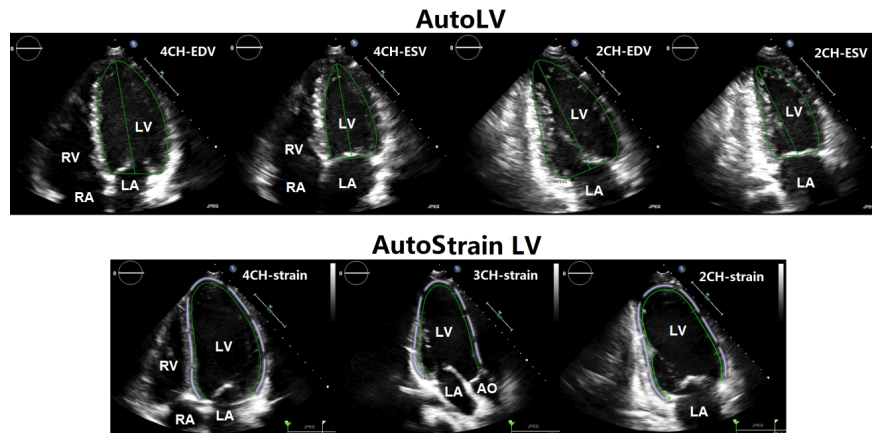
AutoLV and AutoSTRAIN tracking. Top panels show the LV endocardial tracking in apical 4-chamber and 2-chamber views at end-diastole and end-systole by AutoLV. Bottom panels show the LV strain tracking in apical 4-chamber, 3-chamber and 2-chamber views by AutoSTRAIN.
